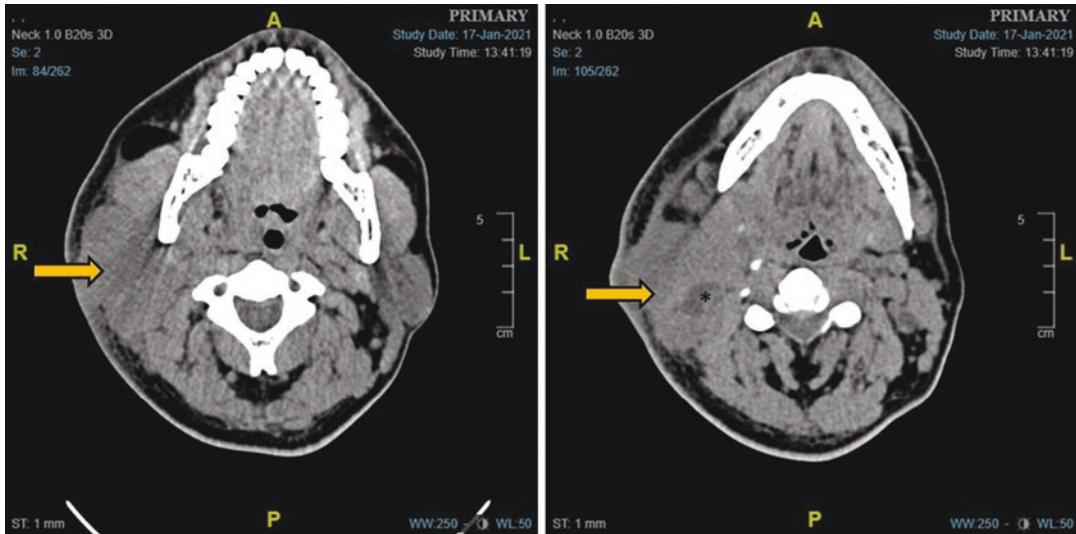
CT scan of right parotid gland showing a heterogenous mass (arrow) arising from the superficial lobe of parotid gland
